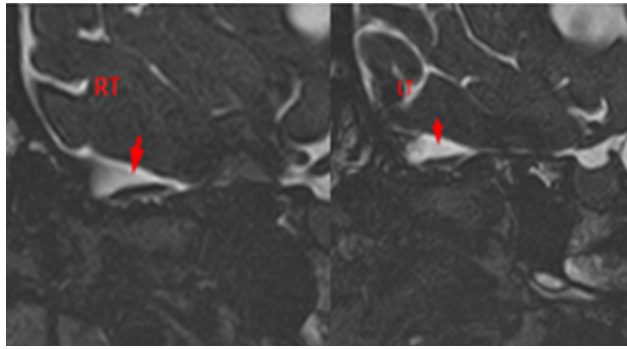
Sagittal T2 MRI radiological assessment of olfactory pathway revealed: Subtle thickening and clumped appearance of the left olfactory nerve filia.
